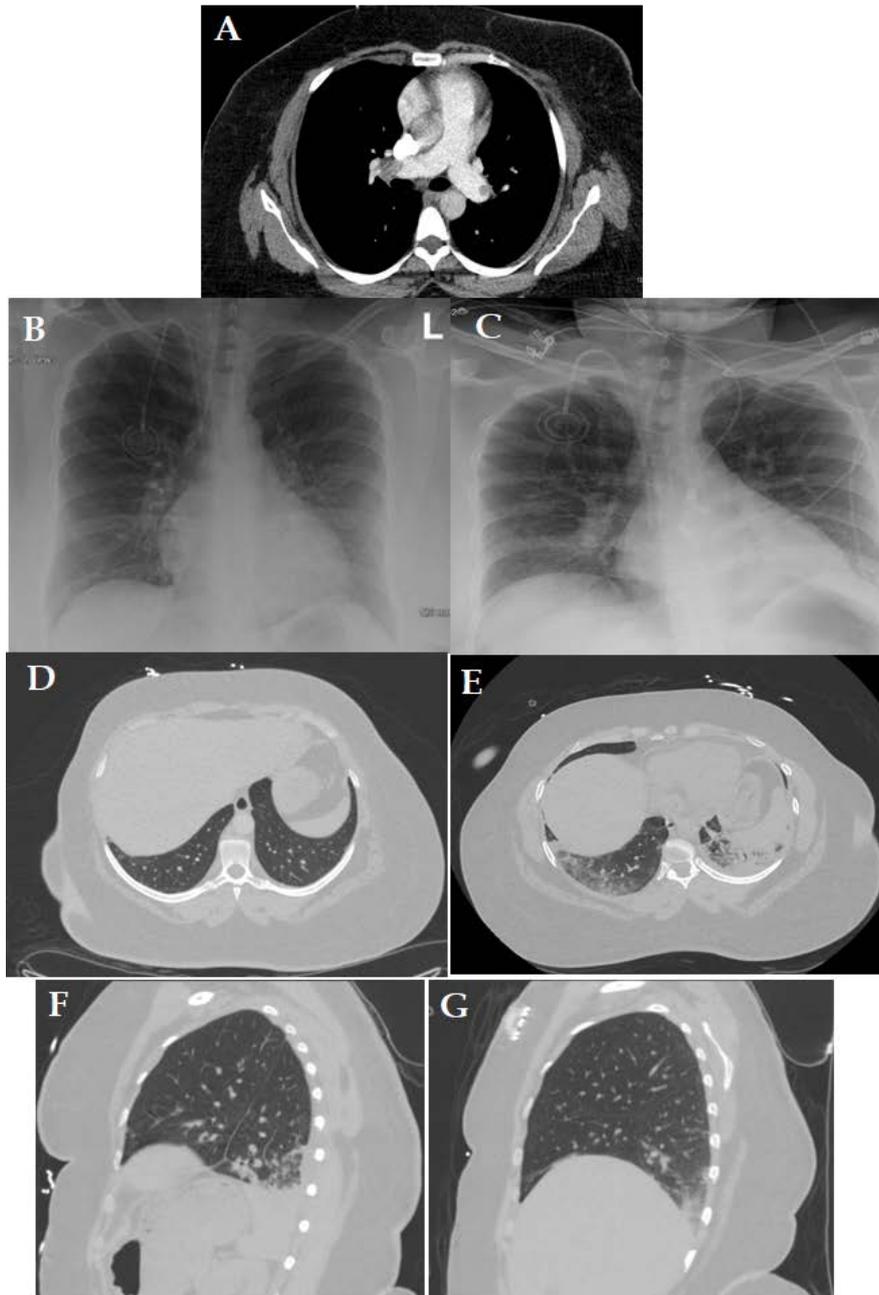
A: Computed tomography (CT) of the showing origin of a large filling defect of the right pulmonary artery (white arrow) extending into the superior lobar, posterior segmental, interlobar, lateral basal segmental, and posterior basal segmental arteries. Additionally seen is the origin of a smaller filling defect of the left pulmonary artery (white arrow) with extension into the apical segmental, superior lingular, inferior lingular, medial basal segmental, lateral basal segmental, and posterior basal segmental arteries. B: Chest X-ray (CXR, Posterior-Anterior view) on admission with no evidence of airspace disease or edema. C: Portable CXR post catheter directed thrombolysis with new mild bilateral airspace disease and mild pulmonary vascular congestion. D: CT Chest at baseline (pre-catheter directed thrombolysis). E: CT of the base of lungs post thrombolysis revealing bibasilar atelectasis, areas of consolidation in both posterior bases and a small left pleural effusion. F: Sagittal view of the left lower lobe with a wedge shaped consolidation. G: Sagittal view of the right lower lobe with a wedge shaped consolidation
